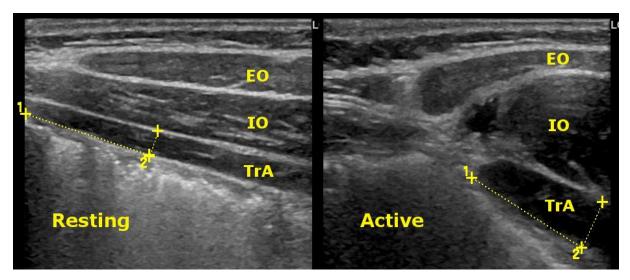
Measurement of the transversus abdominis muscle (TrA) with ultrasound imaging. Resting thickness is shown on the left side, active thickness on the right. Other abdominal muscles – external oblique (EO) and internal oblique (IO) – are also shown. (Figure from Paper II)
